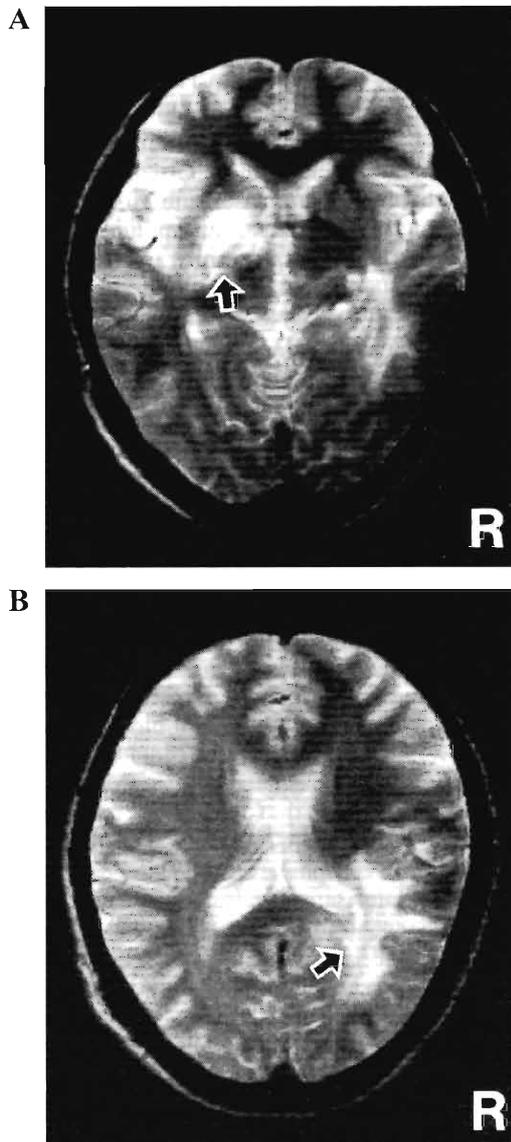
MRI of ADEM associated with chronic active EBV infection A, B: At the time of recurrence, T2-weighted axial MRIs revealed new lesions in the opposite basal ganglia (arrow) and right temporal and parietal white matter (arrow).
